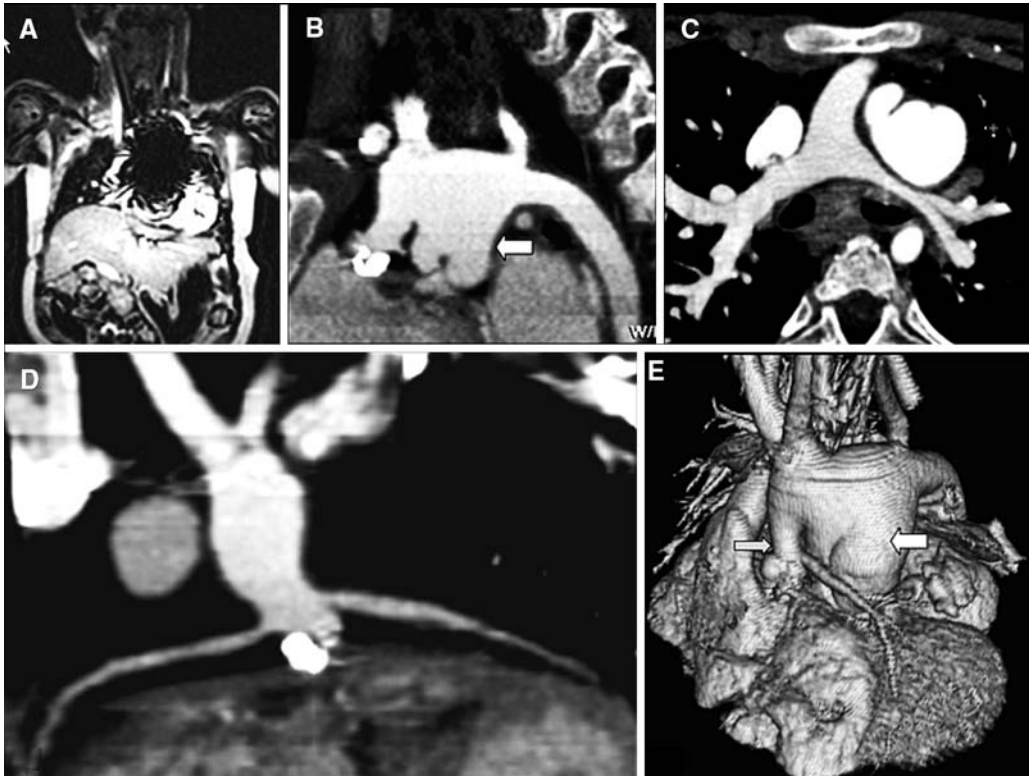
presents an MRI evaluation prior to superior cavopulmonary anastomosis in a patient with hypoplastic left heart syndrome.
